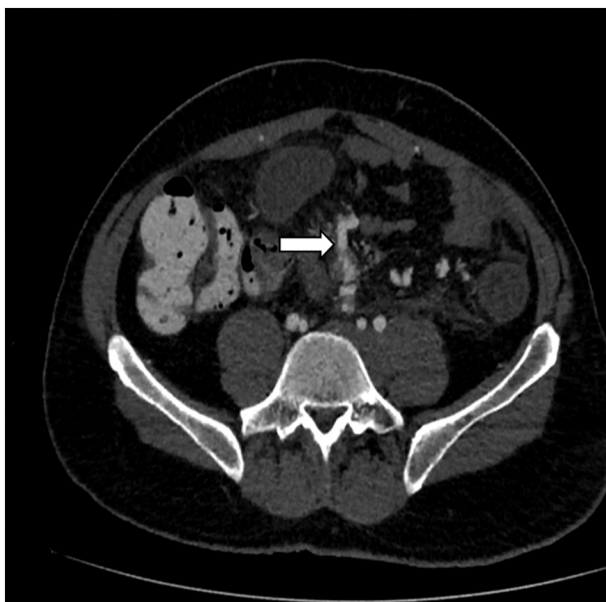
Abdominal computed tomography angiography.
